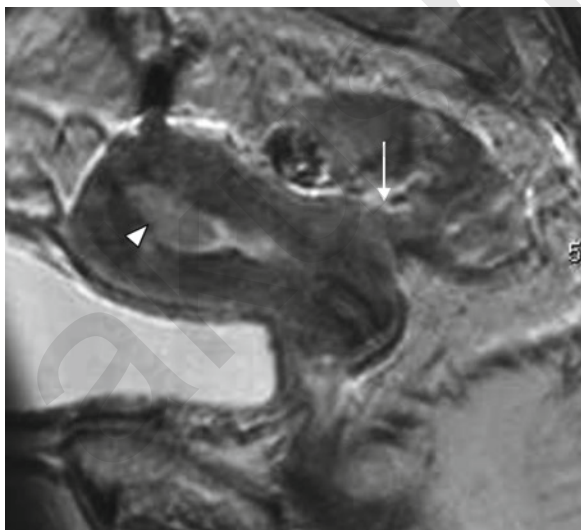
Extensive clear cell endometrial tumour, but clinically confined to the uterus. (a) MR imaging demonstrates extension to involve the cervical stroma (*arrowheads*) and serosal surface of the uterus (*arrow*). (b) Pathologically enlarged external iliac lymph nodes (*arrows*). (c) CT/PET confirms significant uptake
